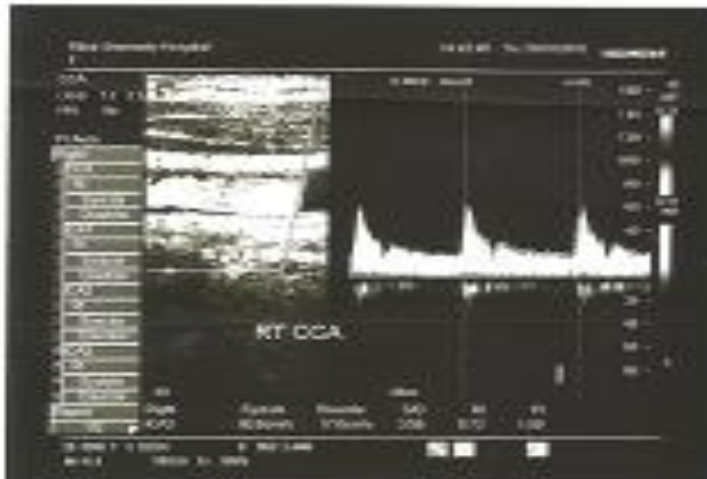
Rt CCA-male-57 year's diabetic patient with normal Doppler parameters.
